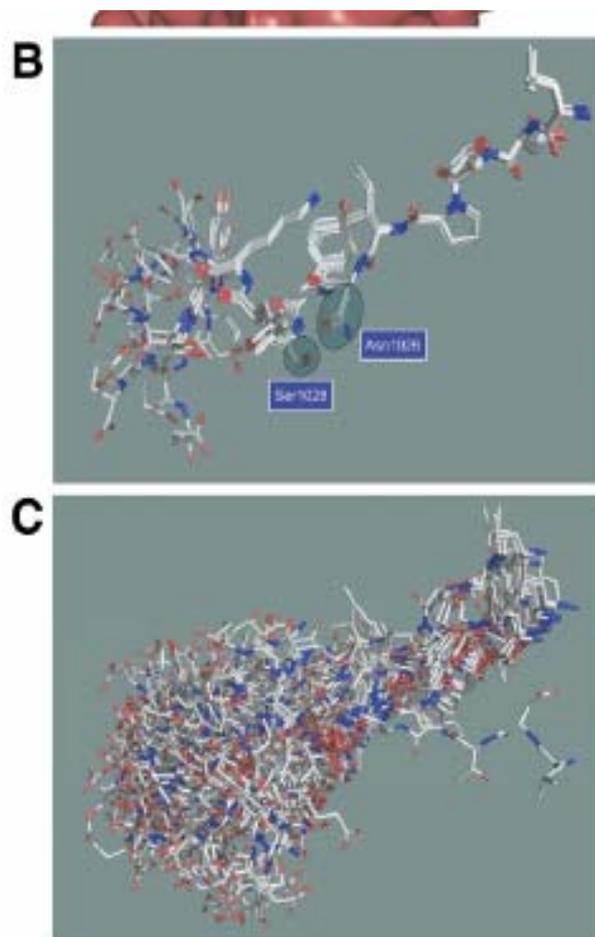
(A) Detail of the interaction between the most populated cluster generated by AutoDock for the WT peptide (green) and the radiograph-calculated structure (yellow) of the same peptide with β -catenin (surface representation). The root mean square deviation was of 0.42 Å between both structures, revealing that redocking was successful and that the parameters used were reasonable. (B) The high degree of overlapping of the 7 multiclusters obtained for the WT indicates the convergence of the model in its interaction with β -catenin. The close proximity of Asn1026 and Ser1028 explains why the side chains of these 2 residues form a hydrogen bond. (C) No consensus structure for the mutant N1026S peptide in its interaction with β -catenin is obtained, probably because of the conformational flexibility induced by the mutation.
